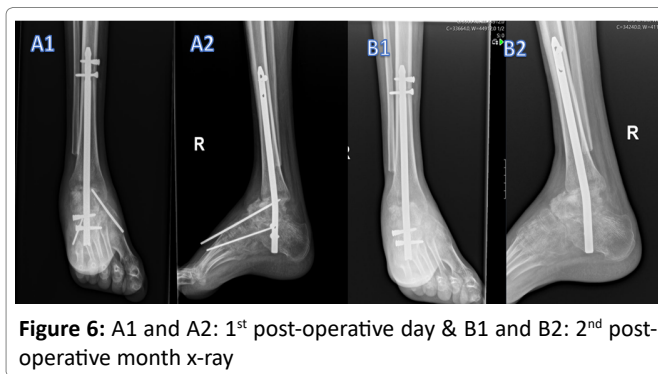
A1 and A2: 1st post-operative day & B1 and B2: 2nd post-operative month x-ray
